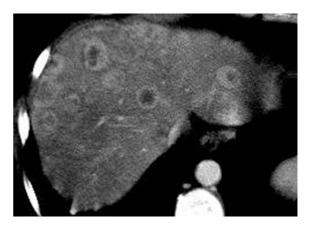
Ring enhancement of metastatic liver lesions from breast cancer. Transverse contrast-enhanced CT image during hepatic venous demonstrates multiple liver lesions showing continuous peripheral rim of enhancement and hypodense necrotic center, consistent with multifocal metastatic liver disease. This enhancement pattern differs substantially from the discontinuous nodular enhancement pattern of hepatic hemangioma
